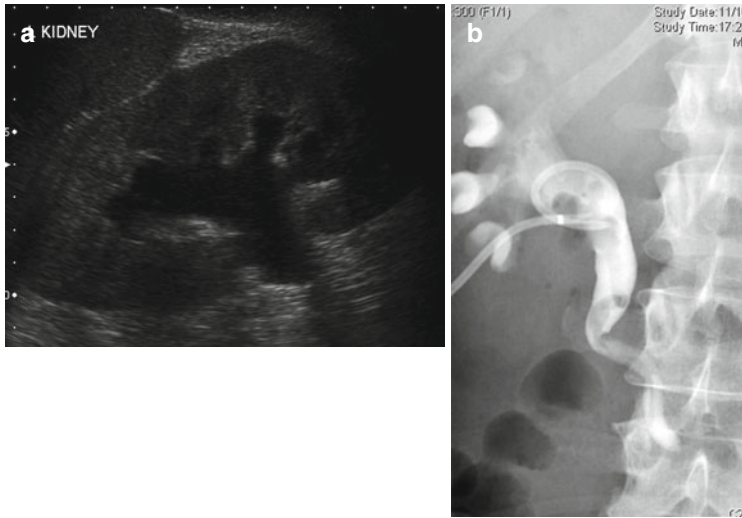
(a) Ultrasound of right kidney shows dilated pelvicalyceal system in keeping with hydronephrosis. (b) Fluoroscopic image following insertion of a percutaneous nephrostomy shows contrast medium within the decompressed pelvicalyceal system
